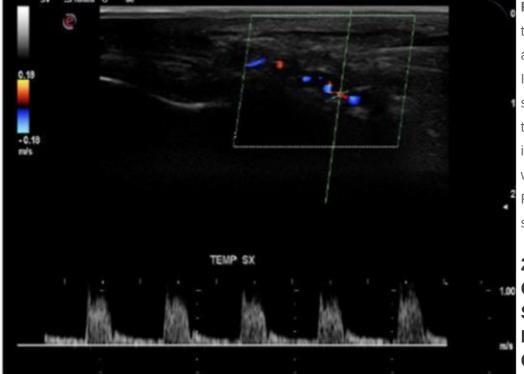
Duplex ultrasound of the right temporal artery-longitudinal view. Indicates a "halo" sign and a stenosis revealed bv turbulent flow and a high PSV in the stenosis area (1 m/s), which is more than twice the PSV in the prestenotic segment of the artery ^[19].
